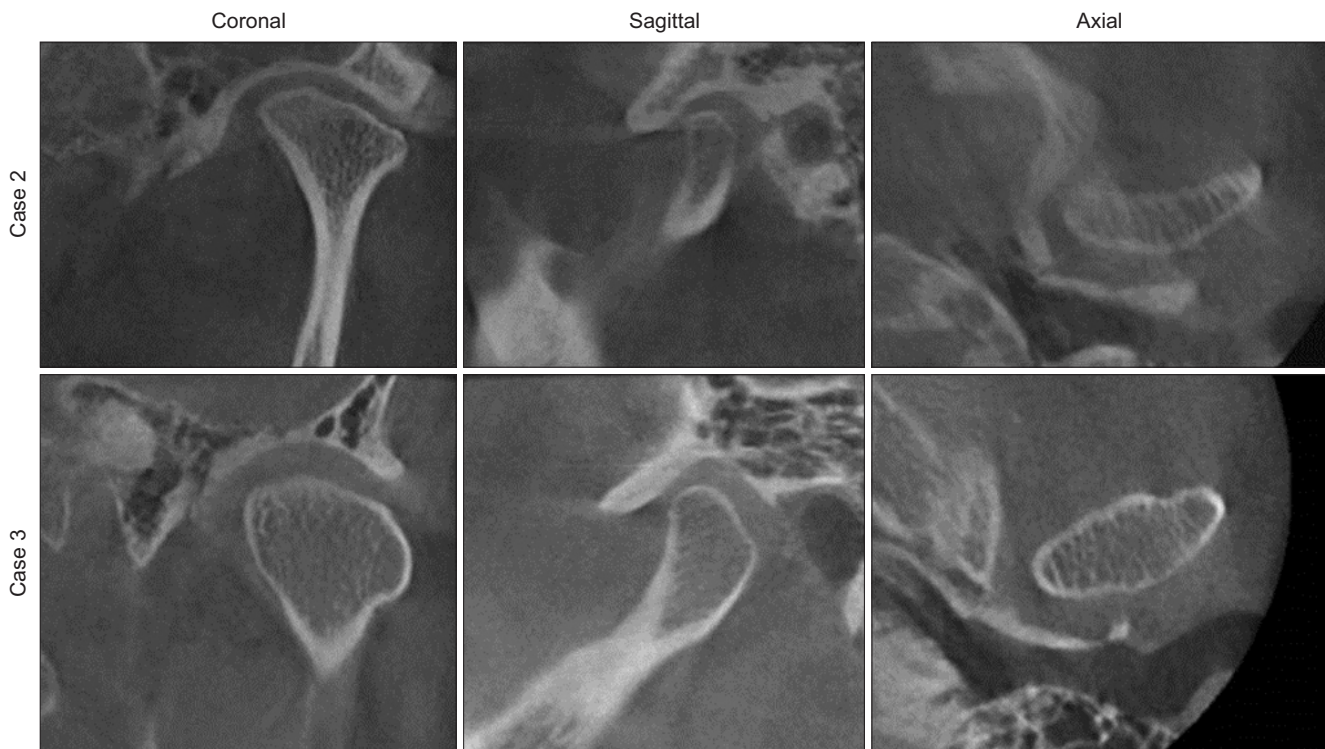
Computed tomography to evaluate condylar contour at the non-osteotomized site more than 3 years after unilateral sagittal split ramus osteotomy. There was no evidence of cortical bone destruction.
